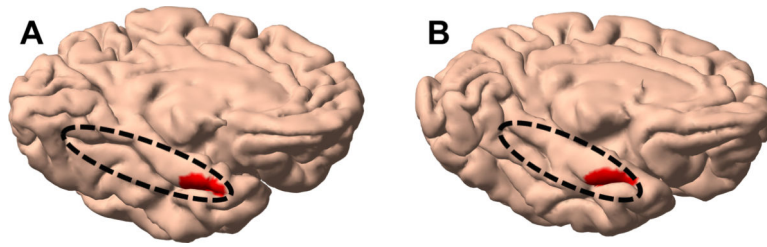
(A) Continuous and (B) discontinuous collateral sulcus, highlighted by the dashed ellipsoids, on left cortical surfaces reconstructed from *in vivo* T1-weighted MRI. The transentorhinal (TE) cortex is also shown in red color.
